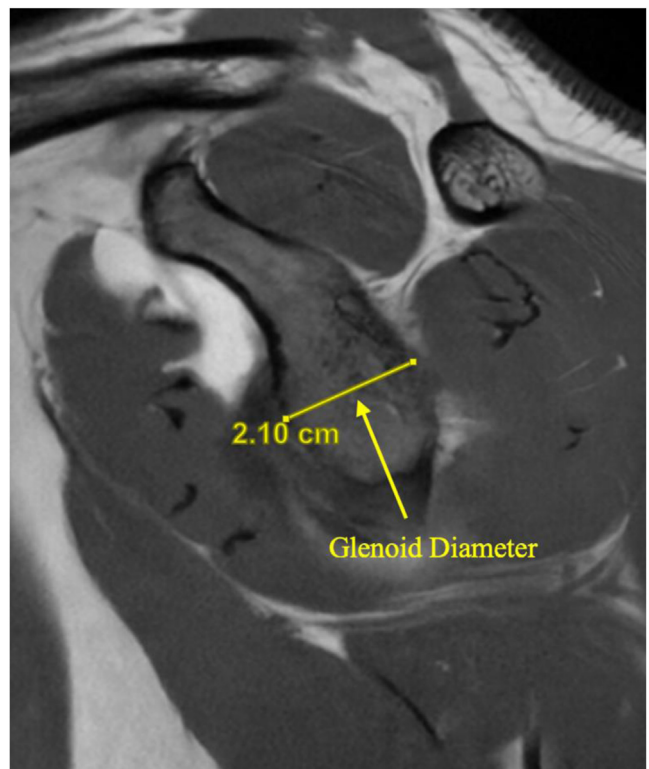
Sagittal magnetic resonance imaging of a left shoulder with measurement of glenoid diameter. Glenoid track = 0.83 (glenoid diameter – width of glenoid bone loss). In this case, there was no glenoid bone loss. Therefore, the glenoid track is 0.83×2.10 cm = 1.74 cm, less than the HSI measured in Figure 1.
